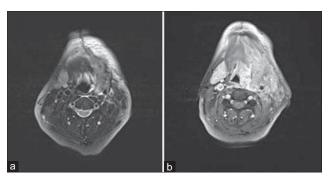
(a) Magnetic resonance imaging finding of local recurrence following radiotherapy and confirmed recurrent tumor by tumor extirpation. (b) Rapid progression only 3 months after salvage chemotherapy
